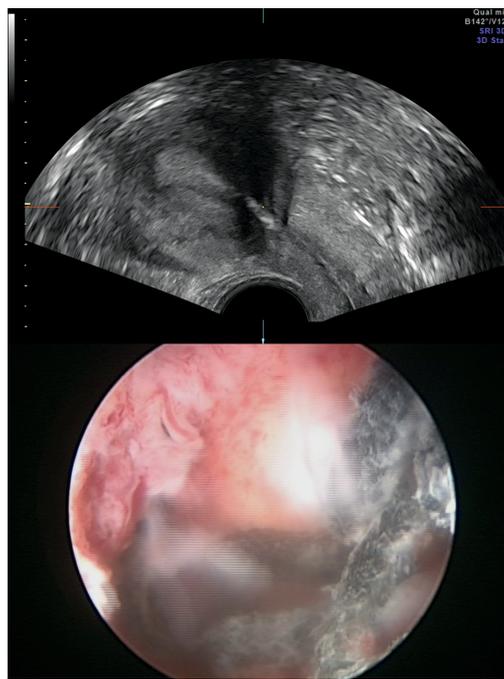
Endovaginal ultrasound-hyperechogenic images in the isthmus part of the uterus and hysteroscopy image-unabsorbed suture material in the uterine cavity on the anterior wall.
